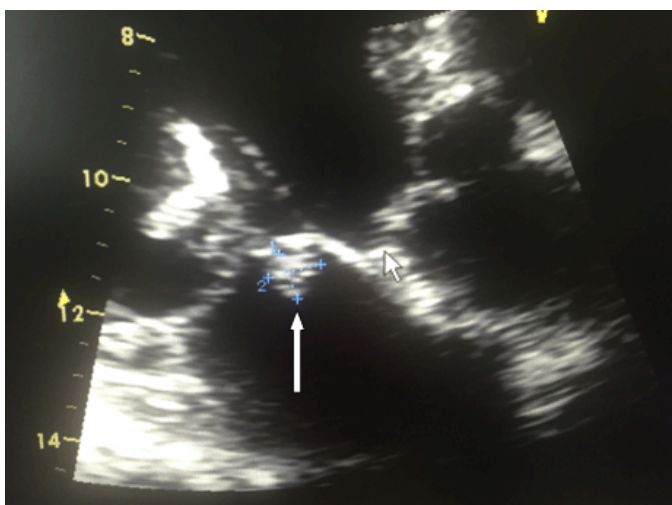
Echocardiogram from the patient showing the vegetation in the outflow side of mitral valve (long arrow).
